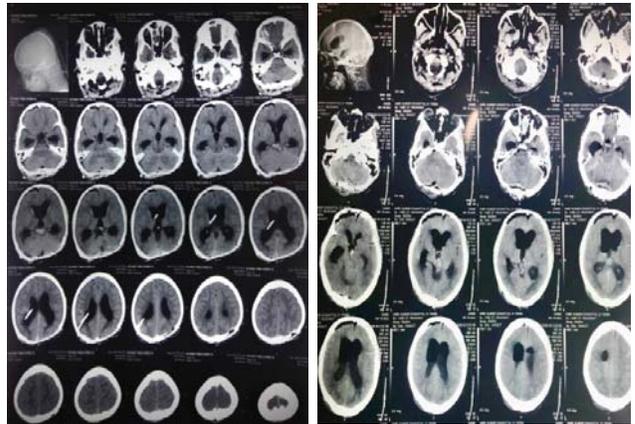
Post-operative CT Scan showing total excision of the tumor with pneumocephalus and pneumoventricle.
